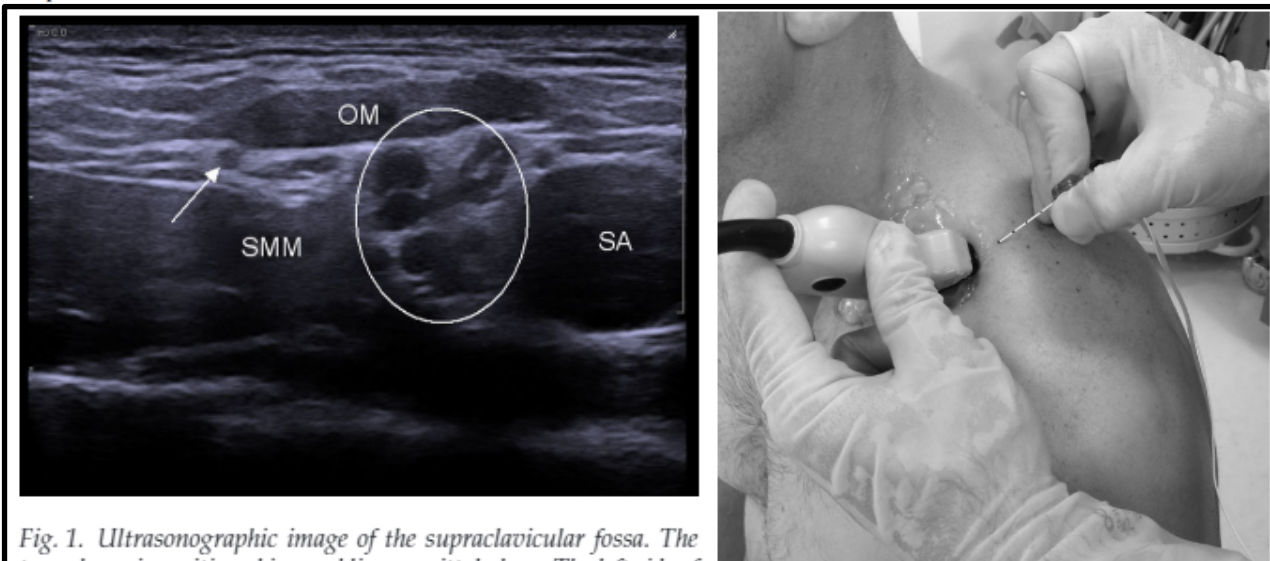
Ultrasonographic image of the supraclavicular fossa. The transducer is positioned in an oblique sagittal plane. The left side of the image is oriented posterolaterally. Important landmarks are the subclavian artery (SA), the omohyoid muscle (OM), the scalenus medius muscle, and the supraclavicular part of the brachial plexus (encircled). The arrow marks the suprascapular nerve (SSN) in a fascia layer under the OM in close relation to the brachial plexus.
